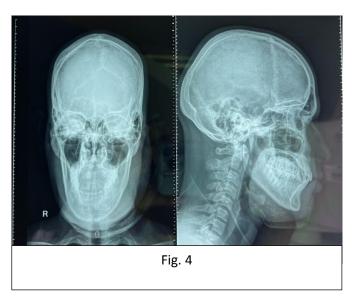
shows post-operative X-ray skull AP and lateral view showing no retained foreign body or any bony involvement
